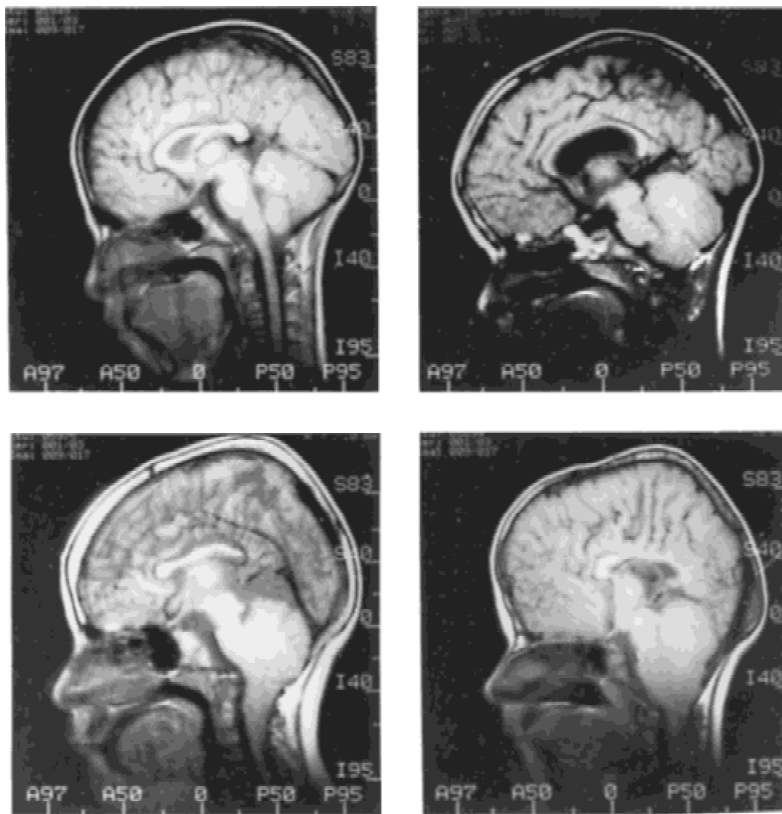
Midsagittal slice from MRI of a normal child (upper left panel), and children with shunted hydrocephalus having spina bifida meningocele (lower left panel), aqueductal stenosis (upper right panel), and prematurity intraventricular hemorrhage (lower right panel). (Reprinted with permission from Fletcher et al., 1995.)
